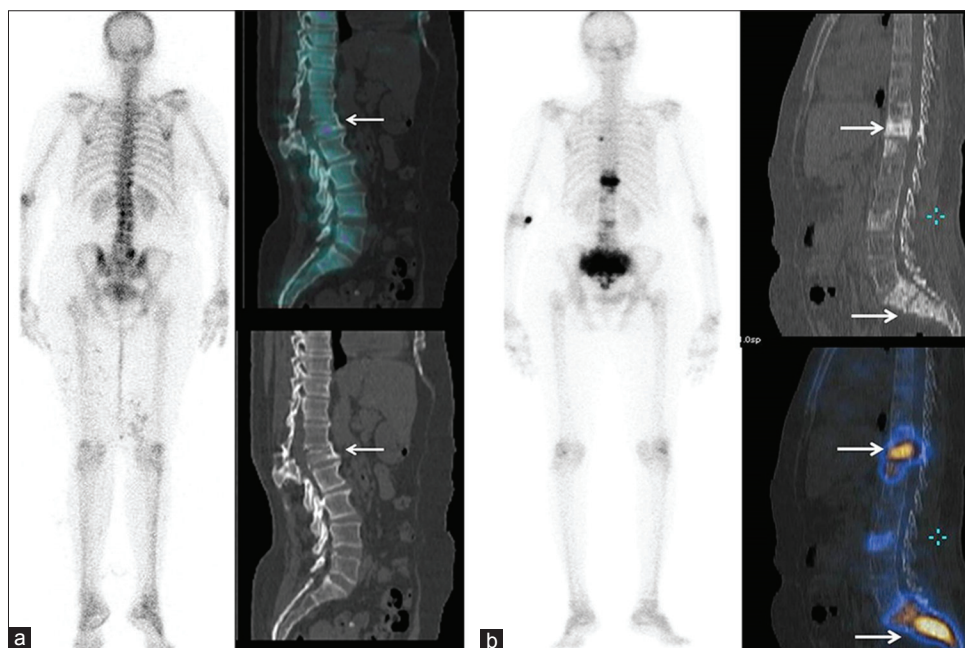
FDG-PET images (A) in a patient with mild/grade 1 fracture in L1 vertebra do not show any significant radiotracer uptake suggestive of osteoporotic fracture. FDG-PET images in a patient with pathological fractures (B) show multiple areas of radiotracer uptake in sacrum and D10 vertebrae (arrows). L3 vertebra is sclerotic but without any uptake, likely osteoporotic fracture
